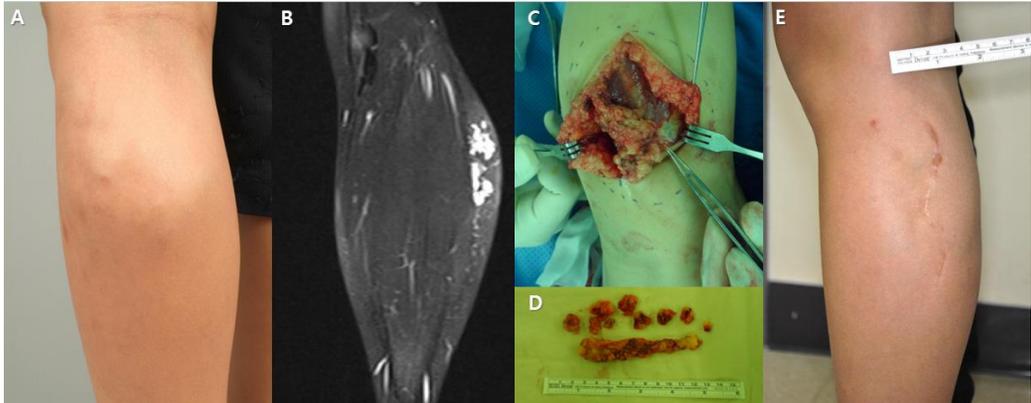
Grade 3 patient. A patient with grade 3, left lower leg, Preoperative photograph. (B) Preoperative MRI, coronal view About 8 cm-sized ill-defined lesion at the left lower leg subcutaneous area. Preoperative T2-weighted sequence MRI, transverse view of lesion side. High signaled mass. Demonstrates typical enhancement. (C) Intraoperative photograph, surgery was performed with w-shape excision line. (D) Excised venous malformation. (E) Post-operative medical photograph took from out clinic in POD 1558.
